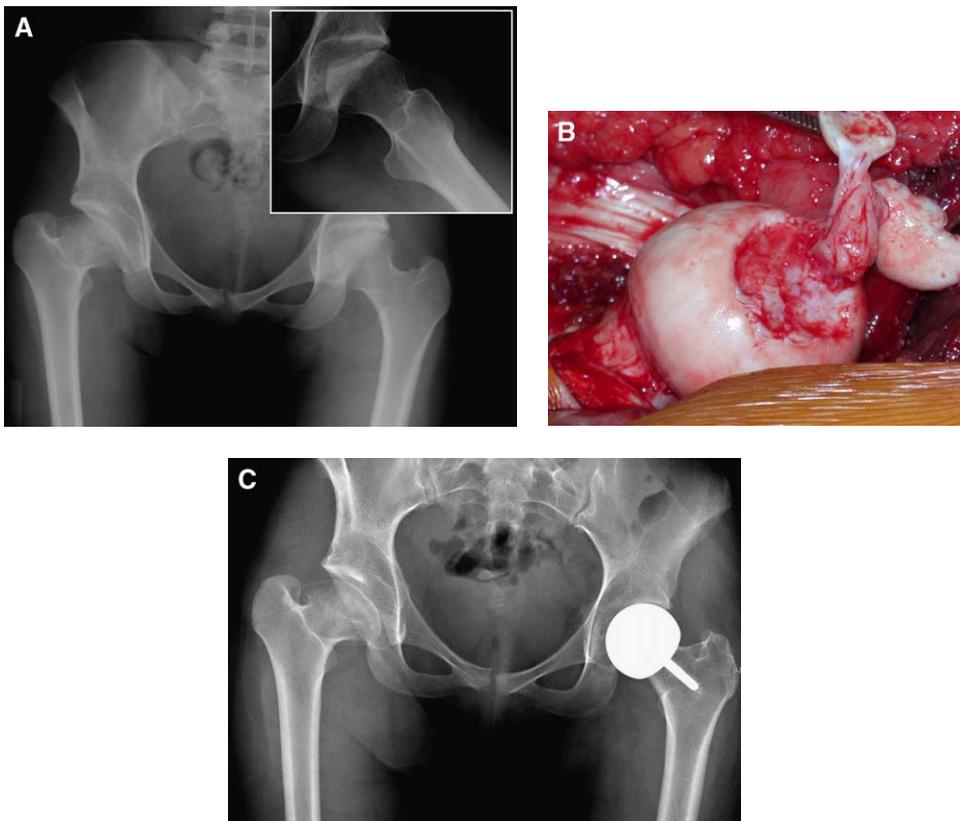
(A) Anteroposterior radiograph and frog lateral radiograph (*inset*) showing the large osteochonral defect of the weight-bearing area of the femoral head. (B) Intraoperative photograph showing the femoral head before preparation. (C) Anteroposterior radiograph 18 months posthemiresurfacing arthroplasty.
